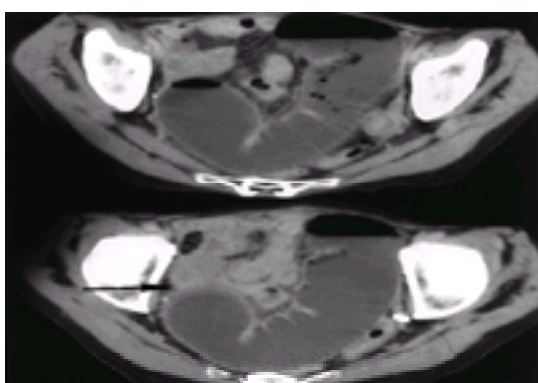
CT shows small-intestinal obstruction caused by adhesions (arrow) [reproduced from [Nolan \(1998\)](#) with permission].
